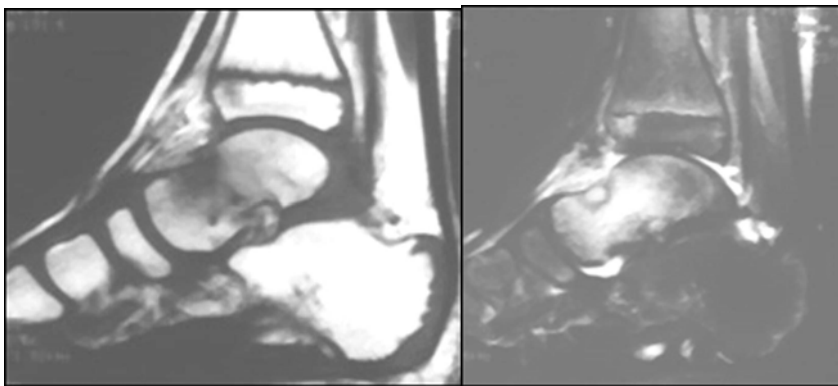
T1 and T2 MRI shows signal intensity changes involving the neck of the talus.
